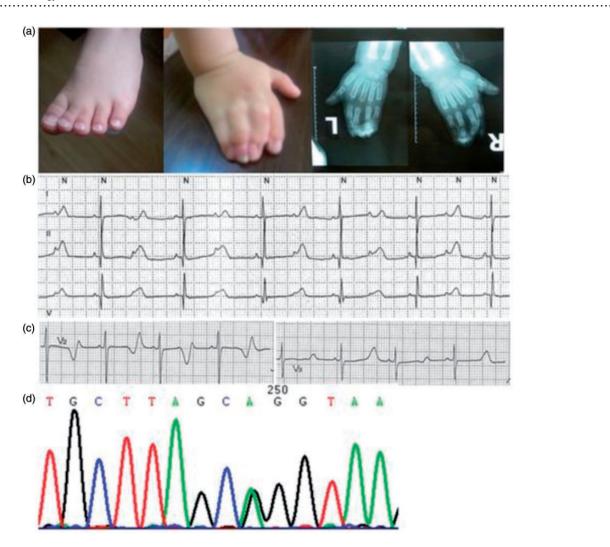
Phenotype and genotype of a TS1 patient. Bilateral syndactyly of two to five fingers confirmed by X-ray and cutaneous syndactyly of two to three left toes (a). Holter tracings demonstrated marked QT prolongation, functional 2:1 AVB with the blocked P wave landed on the ascending limb of T wave (b). Macro-TWA (c). DNA sequences of the TS1 patient: a heterozygous G/A at position 1216 as c.1216G>A transition leading to the p.Gly406Arg (G406R) missense mutation in exon 8A of the CACNA1C gene (d). (With permission from Xiaolin Xue *et al.*⁴). (A color version of this figure is available in the online journal.)
